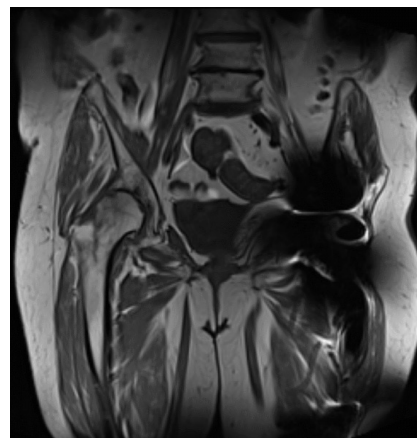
T1-weighted magnetic resonance image of the right hip.
